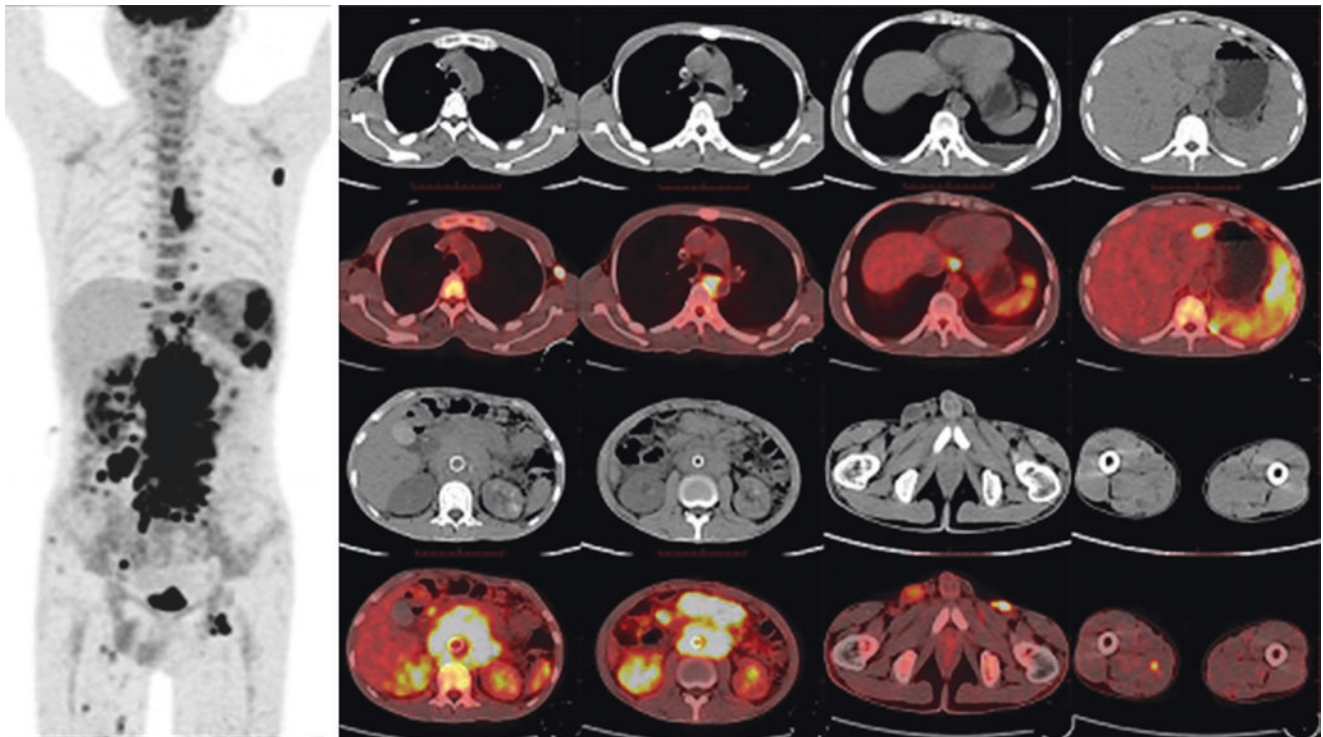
PET/CT showed multiple enlarged lymph nodes in the left axillary, mediastinum, right hilar, left internal mammary, diaphragm, hepatic portal, small omental bursa, retroperitoneal, mesenteric area, the right fossa, basin on the right side, on both sides of the inguinal region and right leg muscle clearance, and showed intense FDG uptake
